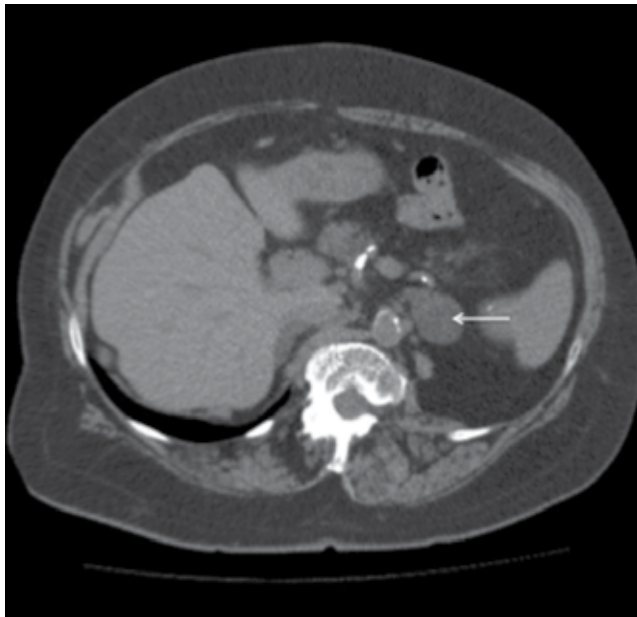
A 72-year-old female with 2.6 cm low-attenuating homogenous left adrenal mass (arrow) on noncontrast CT of the abdomen consistent for adrenal adenoma.
